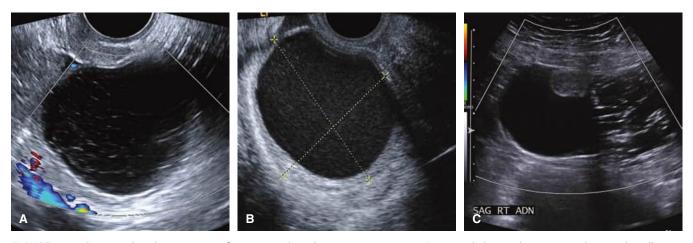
Sonographic characteristics of common adnexal masses in pregnancy. A. A simple hemorrhagic cyst with smooth walls and an internal reticular pattern is characteristic of a physiological corpus luteum cyst. B. Homogeneous cystic mass with diffuse internal low-level echoes suggestive of an endometrioma or hemorrhagic corpus luteum. C. Mature cystic teratoma (dermoid cyst) appears as a complex adnexal cyst. On the right side, hyperechoic lines and dots represent hair in both longitudinal and transverse planes. At the central superior aspect of this cyst, a mural nodule—the Rokitansky protuberance—is seen. A fat (*right side*)-fluid (*left side*) level is another common finding with these tumors.
